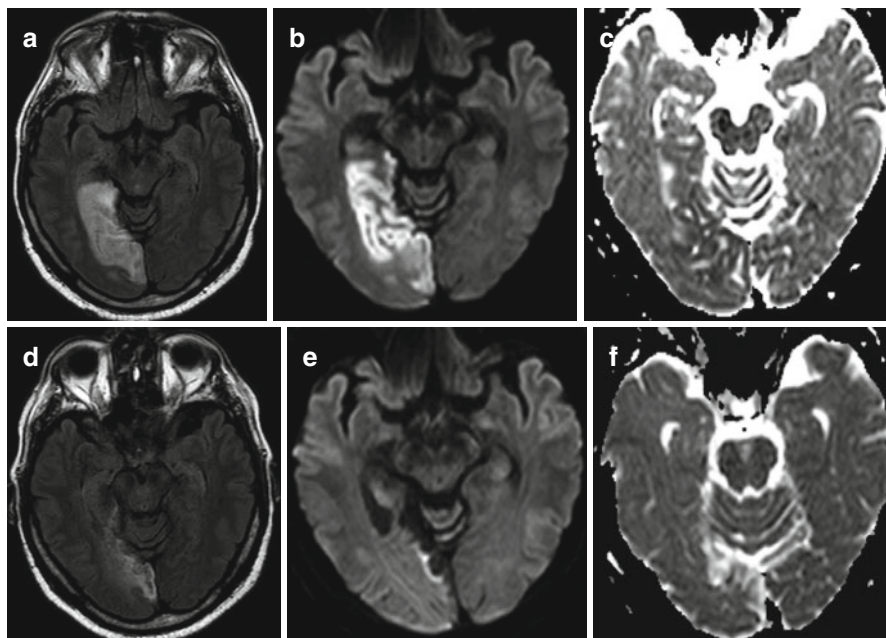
(a–f) Evolution of the lesion in ischaemic stroke in the territory of the right PCA. The same patient as in the Figs. 9.6 and 9.8. FLAIR and diffusion-weighted MR images (a, b) on the fifth day after stroke show a hyperintense lesion in the right occipital lobe indicating the subacute stage of infarction. Normalization of the lesion signal intensity on the ADC map is shown (c). FLAIR image 3 months after stroke shows gliosis and cortex atrophy in the post-infarction area (d). The lesion is significantly smaller than 3 months earlier (in comparison with a). Normalization of the lesion signal intensity on diffusion-weighted image is shown (e). The ADC map shows free diffusion in the post-infarction area (f)
